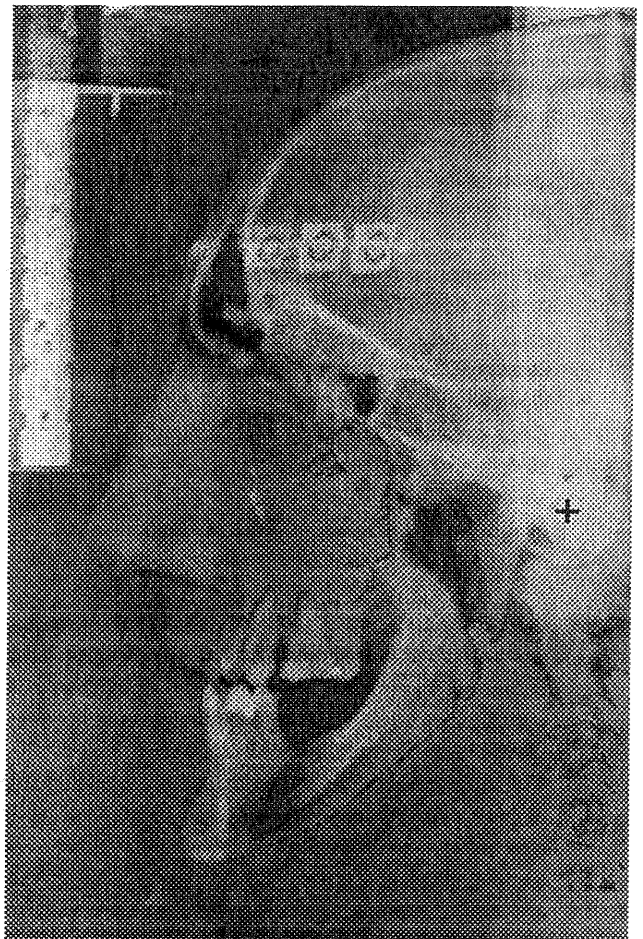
Combined radiograph and digital image of the head.
